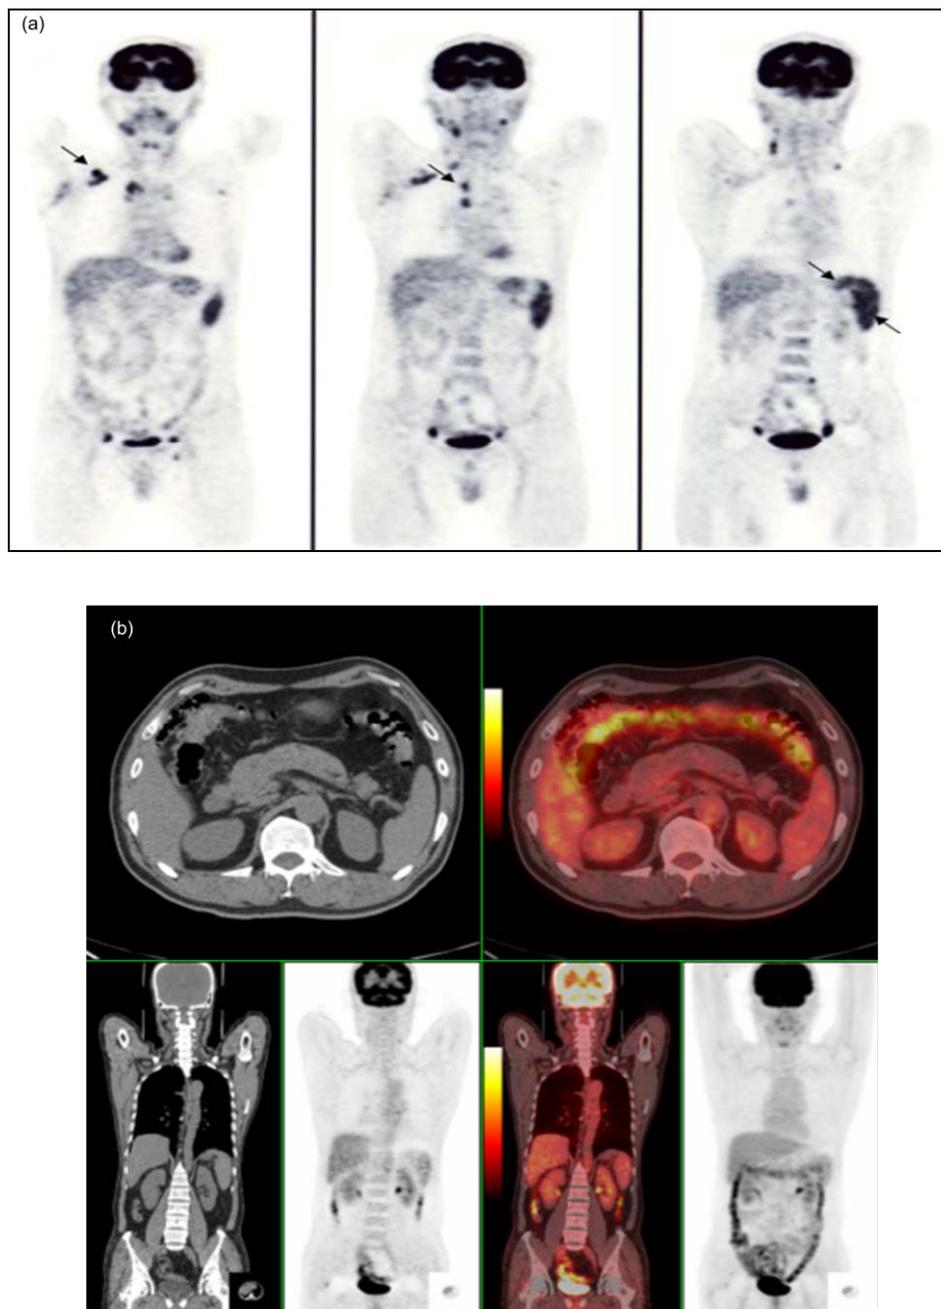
Stage IIIS NHL and splenic involvement in a 58-y-old man before treatment (a) and after six cycles of chemotherapy (b). The coronal PET images demonstrated splenic uptake of ^{18}F -FDG that is more intense than hepatic uptake and multiple high metabolism lymph nodes (black arrows). S/L ratio was 2.1. CT image shows homogeneous appearance of spleen. Splenic index of 450 mL was normal for age (≤ 480 mL=normal). Splenic uptake of ^{18}F -FDG is lower than hepatic uptake. S/L ratio was 0.9. The CT image showed no obvious morphology change of spleen before and after chemotherapy.
